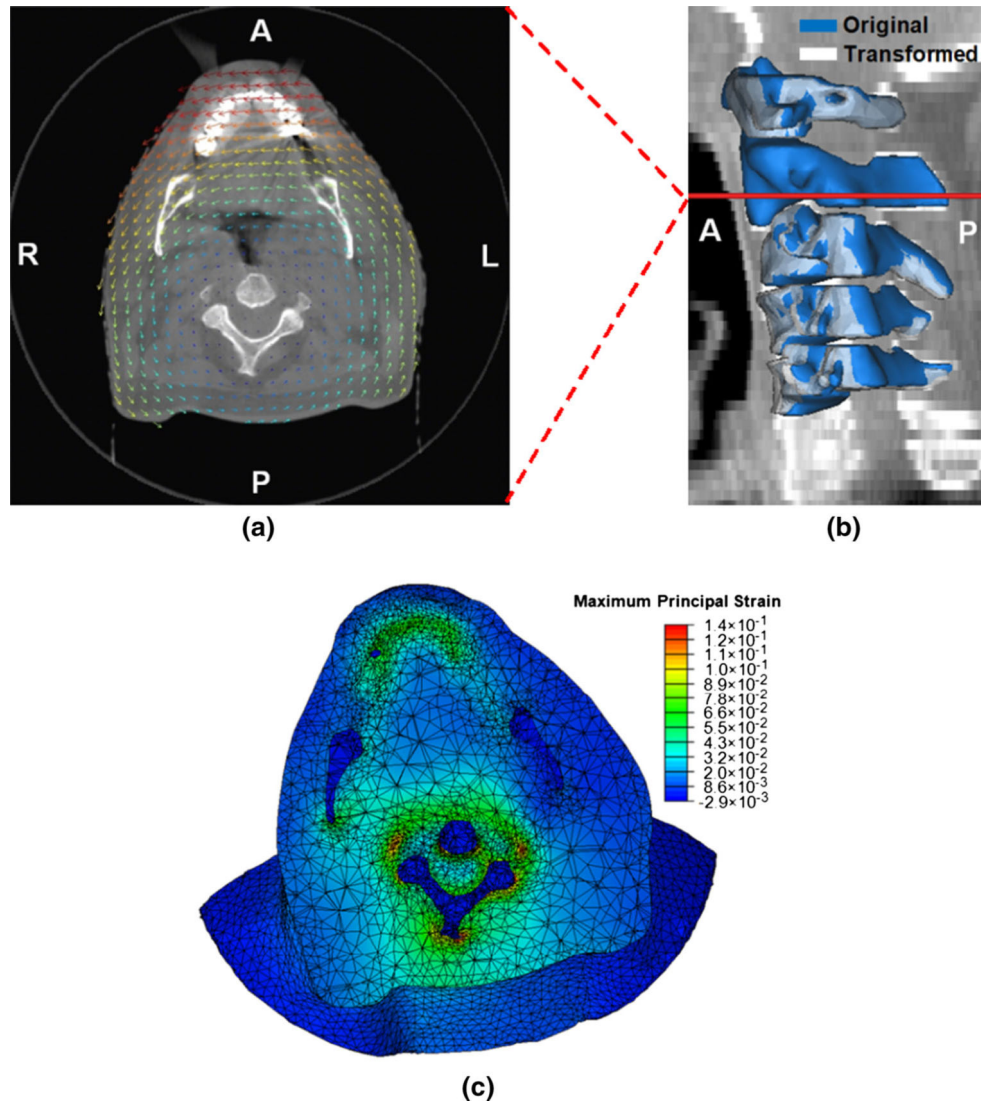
Results of the FE analysis under a combined set of force and displacement boundary conditions: a the displacement vector field overlaid on an axial plane of the cone-beam CT image volume on which the model was constructed (scaled), b the original and transformed geometries of the cervical vertebrae (C1–C5) with the level of the CT slice shown in a annotated, c the maximum principal strain field shown on the deformed geometry (*A* anterior, *P* posterior, *L* left, *R* right)
